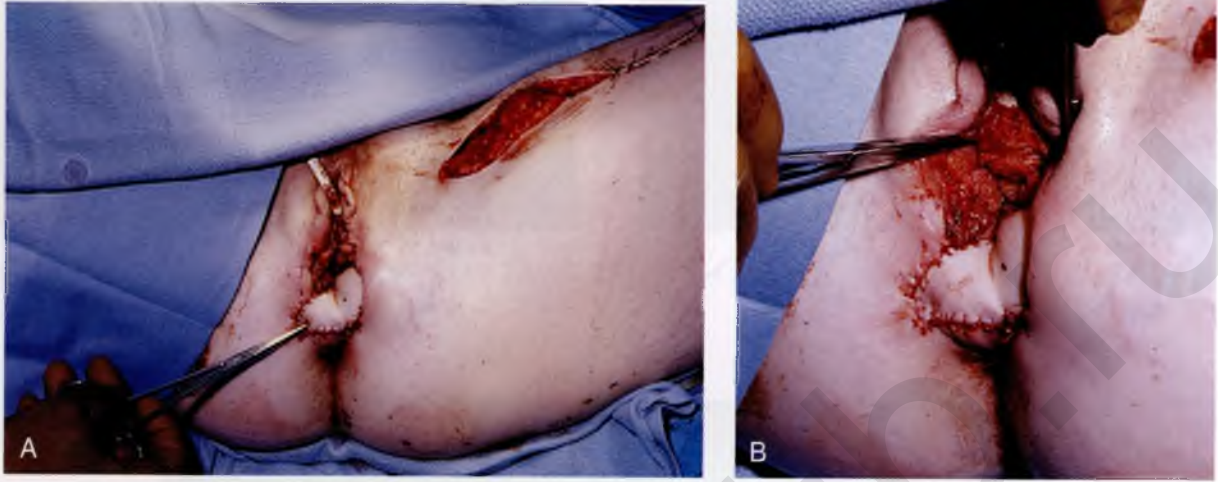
A. The muscle, together with the overlying skin and subcutaneous tissue, constitutes the pedicle graft. This graft is rotated and delivered via a tunnel through the thigh to the labial area. The graft is then sutured into place after testing for the adequacy of blood flow (using Doppler sonography). B. Detailed view of part A. The wound is being closed.
